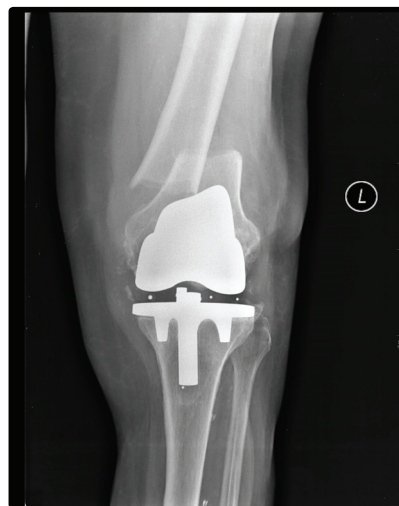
The preoperative AP (1) and lateral (2) x-rays of the patient demonstrating a Rorabeck type 2 supracondylar displaced periprosthetic fracture
